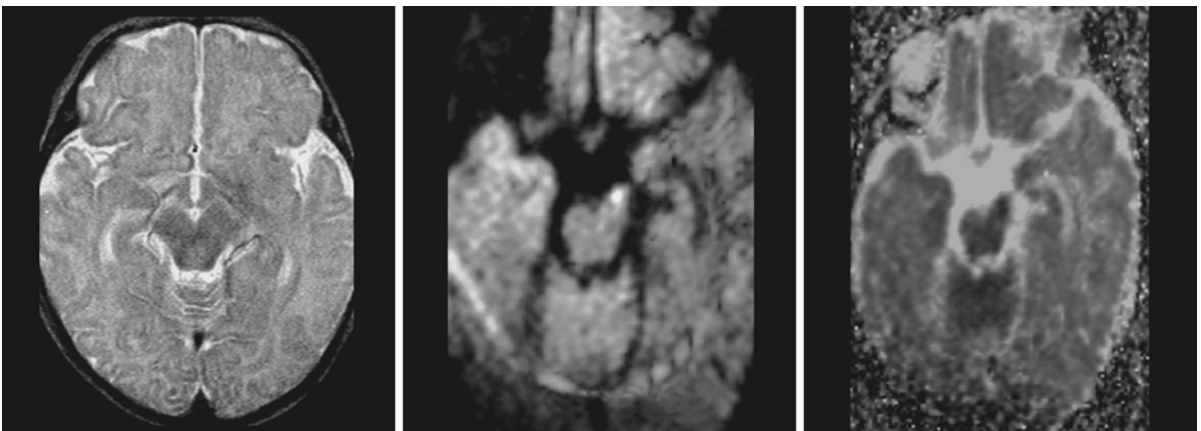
A 5-week-old female infant with onset of seizures 3 days before the MRI. Neurological examination revealed right arm impairment. MRI reveals a left middle cerebral artery infarction. The images at the level of the midbrain are shown. The T₂-weighted image (*left*) reveals no abnormalities. The
